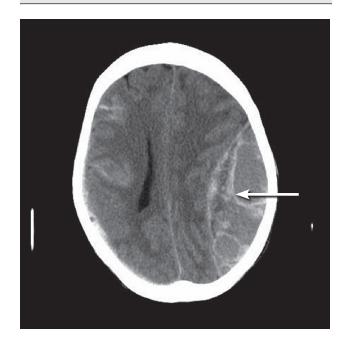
Subdural Hematoma On Computed Tomography
